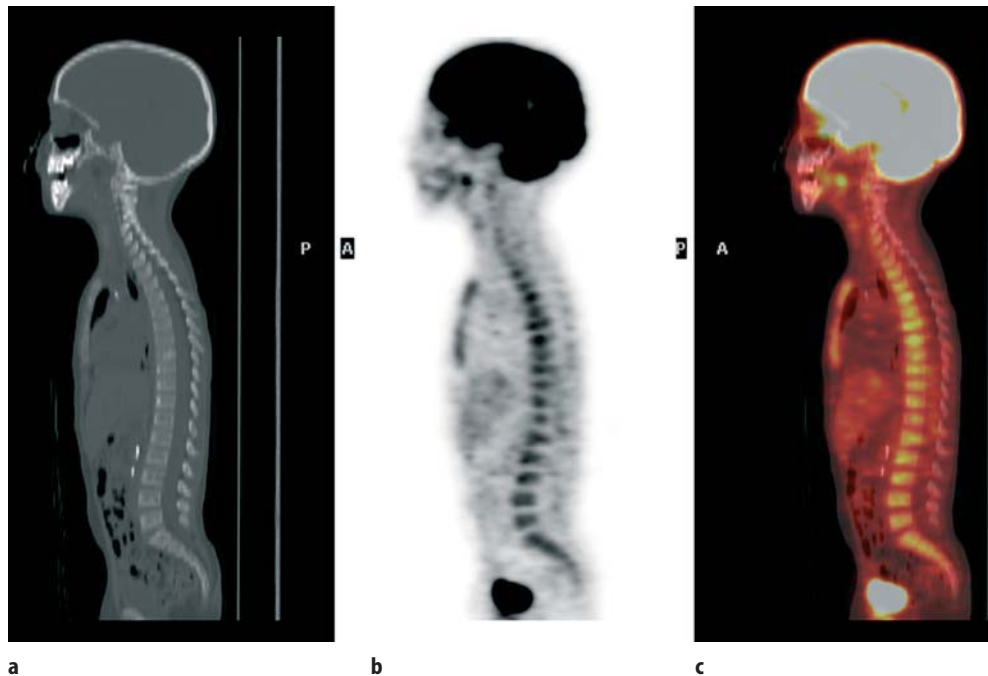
Sagittal images of PET/CT from 4-year-old child undergoing chemotherapy for metastatic Wilms tumor and receiving granulocyte colony-stimulating factor (G-CSF). (a) CT images show bone window. (b) FDG-PET images show uniform increased uptake in the spine and sternum. (c) Fusion images of FDG-PET and CT.
